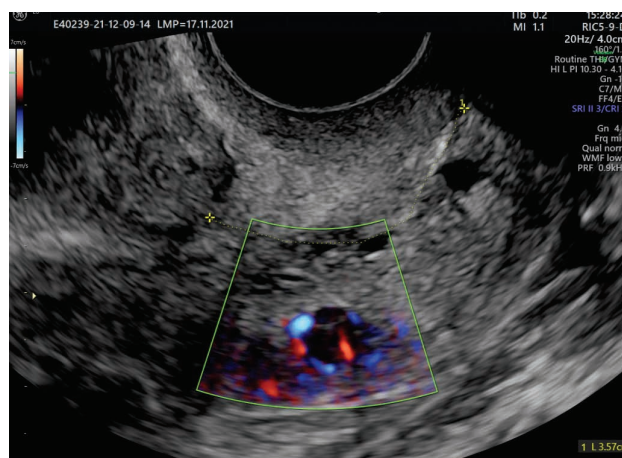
Cervical hypoecogen adenomiosis lesion with translezional flow on color Doppler (personal collection of Roxana Bohîlțea)
